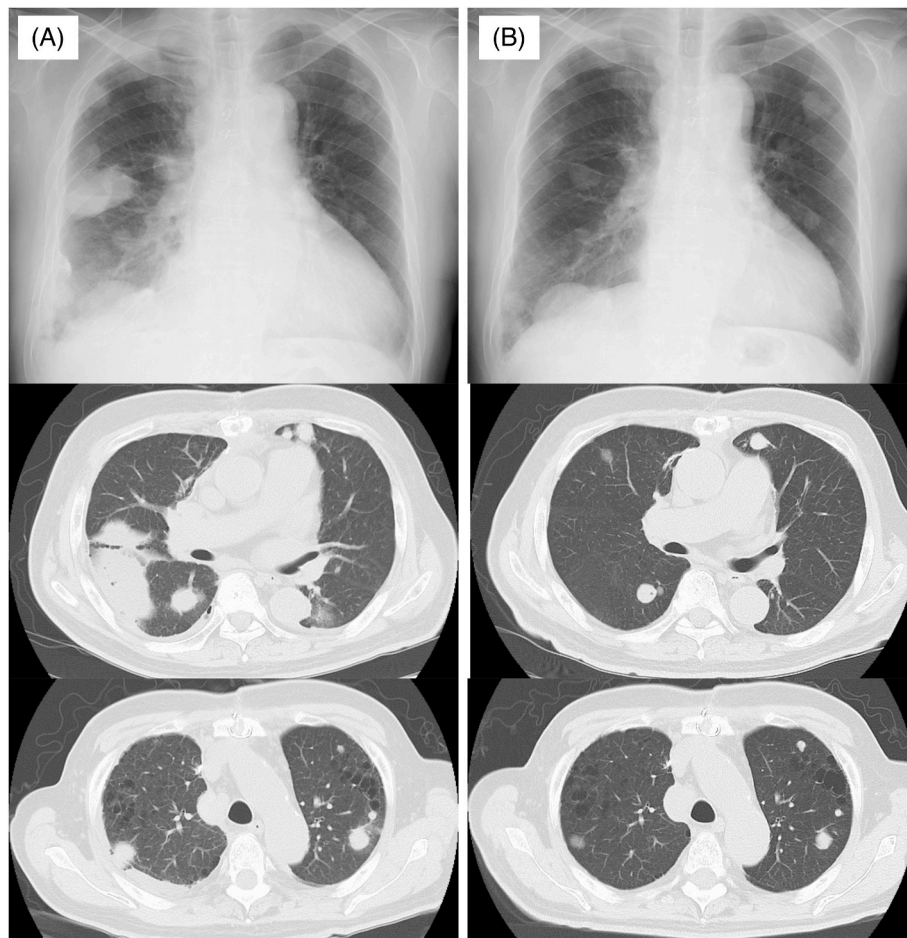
Chest CT and X-ray images before and after lenvatinib treatment. (A) Chest CT and X-ray images (A) before and (B) 28 days after lenvatinib treatment.
